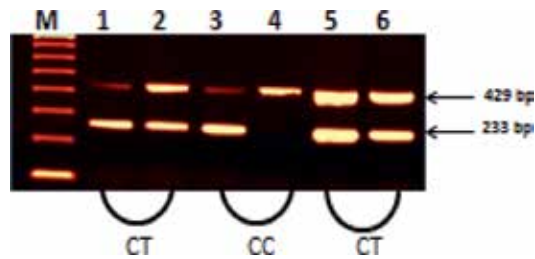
Shows the amplification of IL-10-819C/T genotypes (CT and CC). Lane M: 100-bp DNA marker, lanes 1, 3, and 5: amplification of allele C, lanes 2 and 6: amplification of allele T, 233-bp band for target DNA, 429-bp band for internal control.
